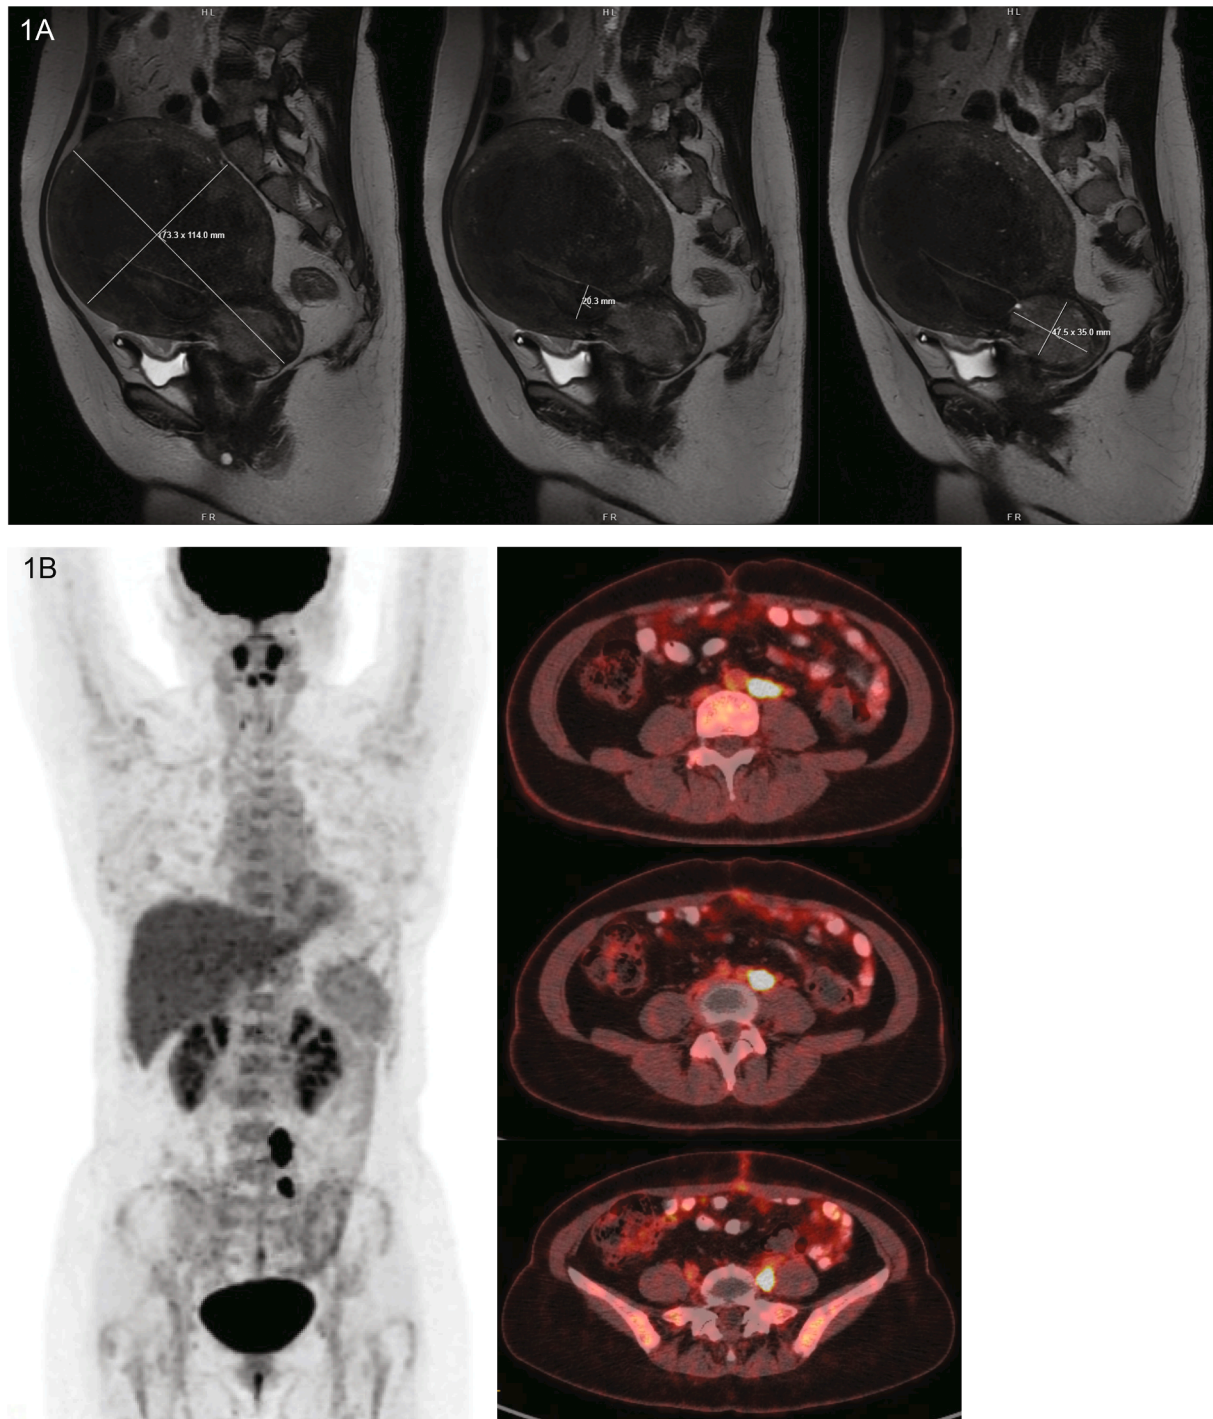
A: Sagittal pelvic MRI images show the extend of intracervical/ lower uterine segment disease with no apparent surface contour involvement. B: Post-operative PET/ CT imaging demonstrates enlarged and hypermetabolic left pelvic (1.4 × 1.3 cm, SUV max 13.6) and *para*-aortic lymphadenopathy (1.8 × 1.1 cm, SUV max 14.8).
